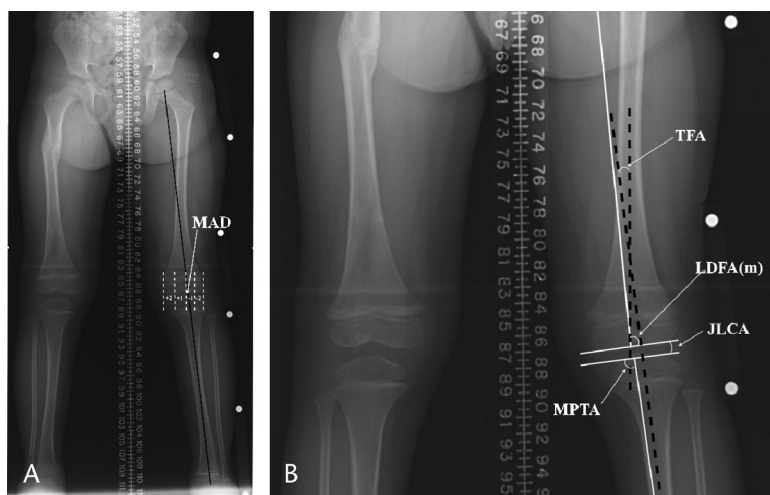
A standing full-length AP radiograph of a 5-year-old boy 5 months after an isolated right-sided femoral shaft fracture. The uninjured left lower extremity was used to measure the frontal plane deformity parameters. A, Landmarks used for measuring the MAD and the mechanical axis station indicating the relationship of the mechanical axis line to the center of the knee joint. B, Landmarks used for measuring the LDFA(m), MPTA, TFA, and JLCA.
